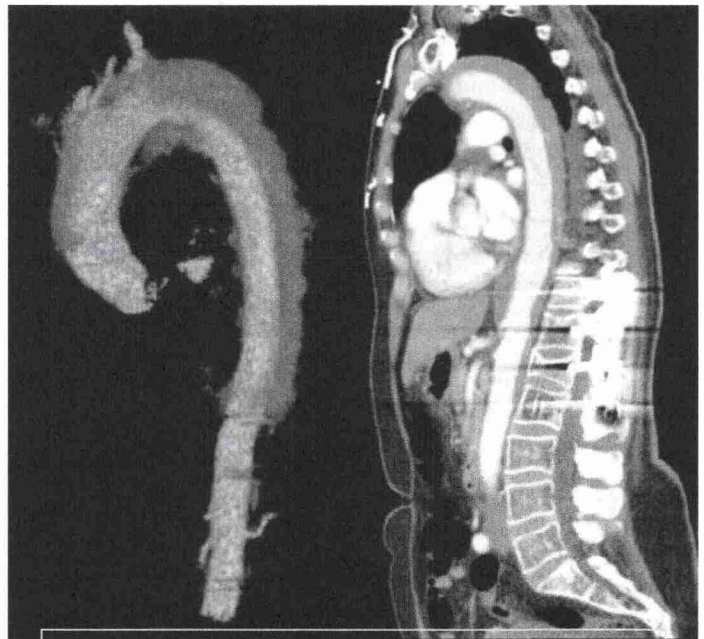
CT Mediastinum of Thoracic Aortic dissection
